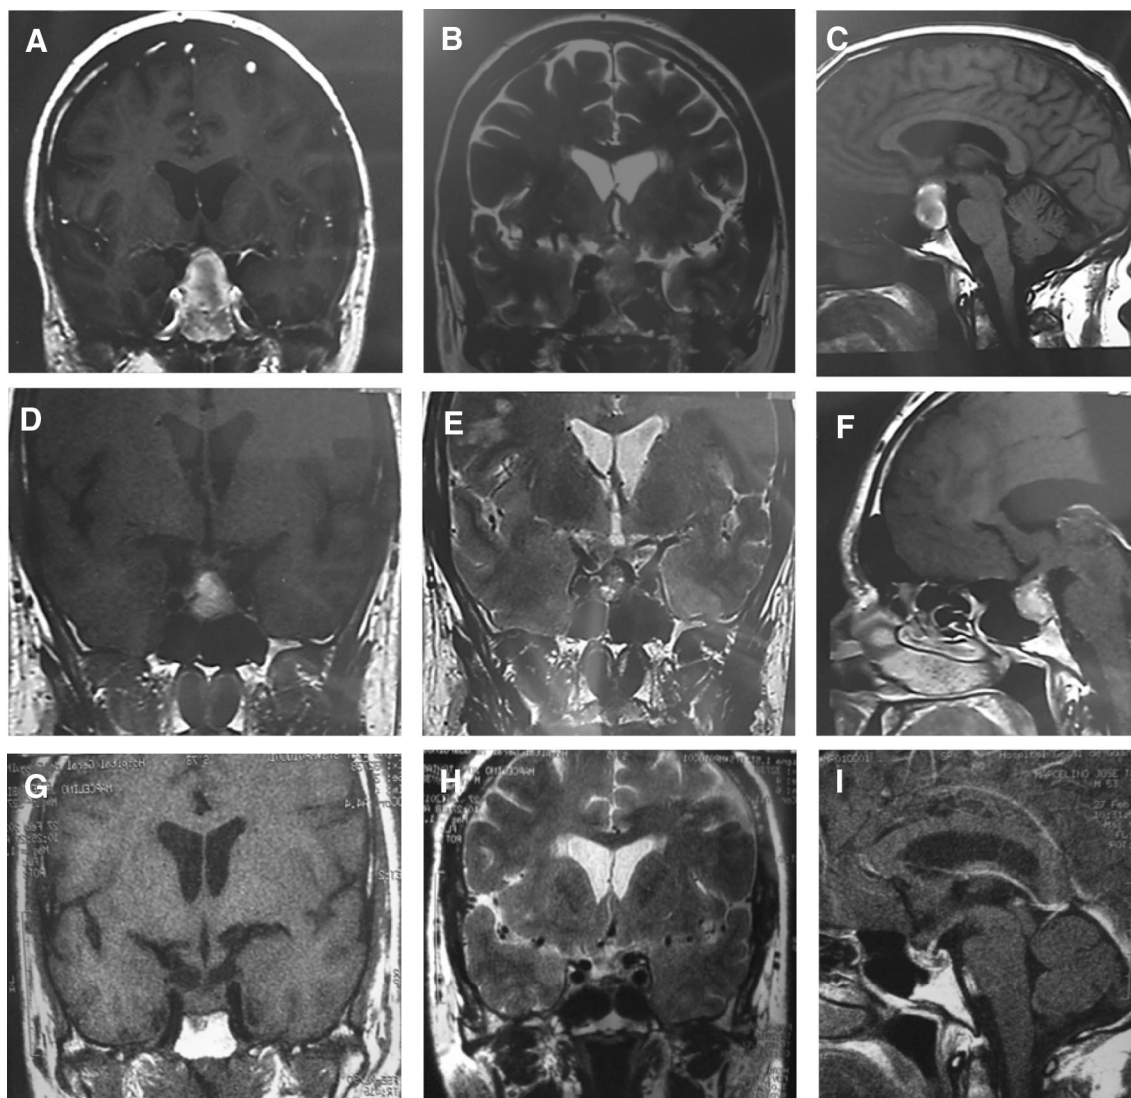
MRI performed 10 days after PA clinical presentation showing a pituitary mass impinging on the optical chiasma, with a peripheral enhancement after gadolinium in a coronal view (a), an iso- to hyperintense signal in a T2-weighted image (b) and areas with hyperintensity in a T1-weighted image without gadolinium enhancement (c). Sellar MRI taken 24 days after the first imaging session showing a reduction in tumour volume, with decreased hyperintensity in a T1-weighted image without contrast (d), hypointensity in a
